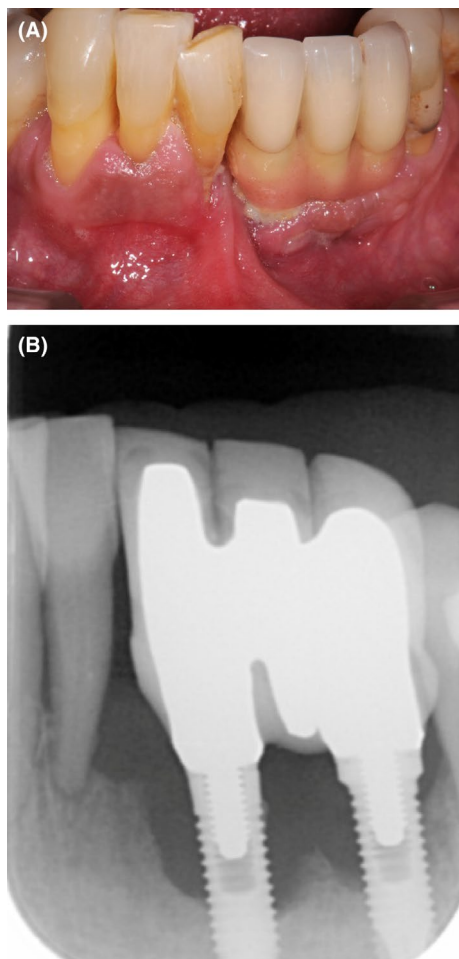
(A) A 3-unit mandibular anterior implant bridge had a prosthetic design that was uncleanable by the patient. (B) The corresponding periapical radiograph showing bone loss as a consequence of peri-implantitis.
